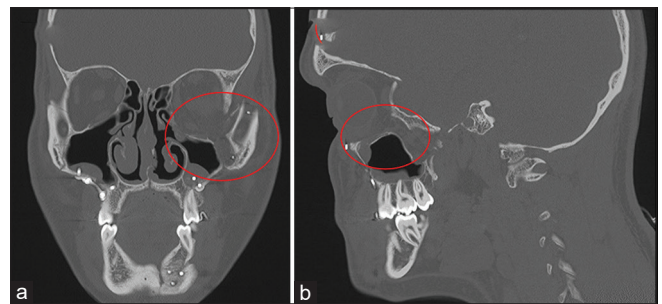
Preoperative Computed Tomographic (CT) images of patient with red circle showing (a) lateral wall and (b) orbital floor fracture with fat herniation
